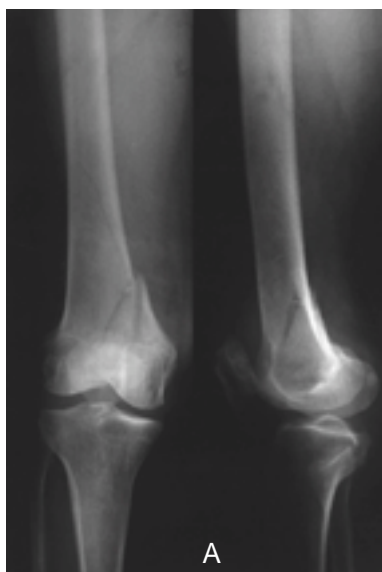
Preoperative radiograph of 66-year-old female shows AO type B2 distal femoral fracture.
